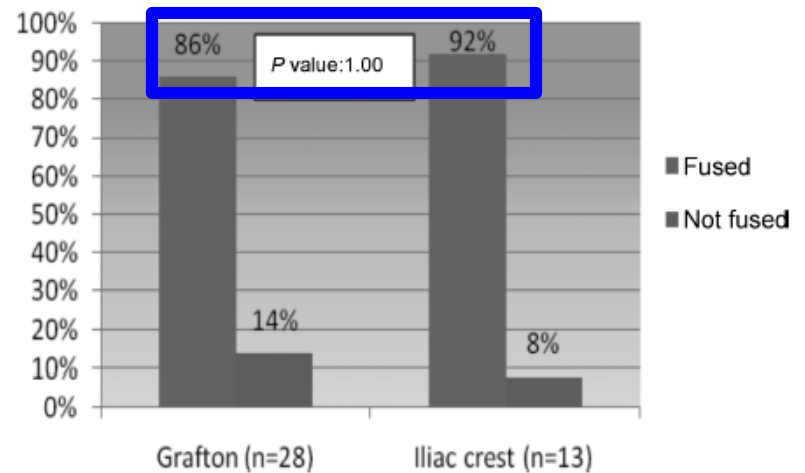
Overall radiographical fusion rates at 2 years. DBM indicates demineralized bone matrix.
